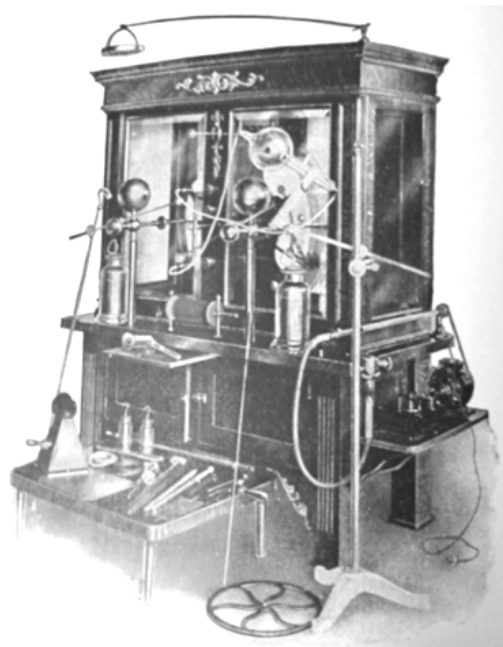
McIntosh Type "A" Model Static and X-Ray Machine (1911)²⁶²
